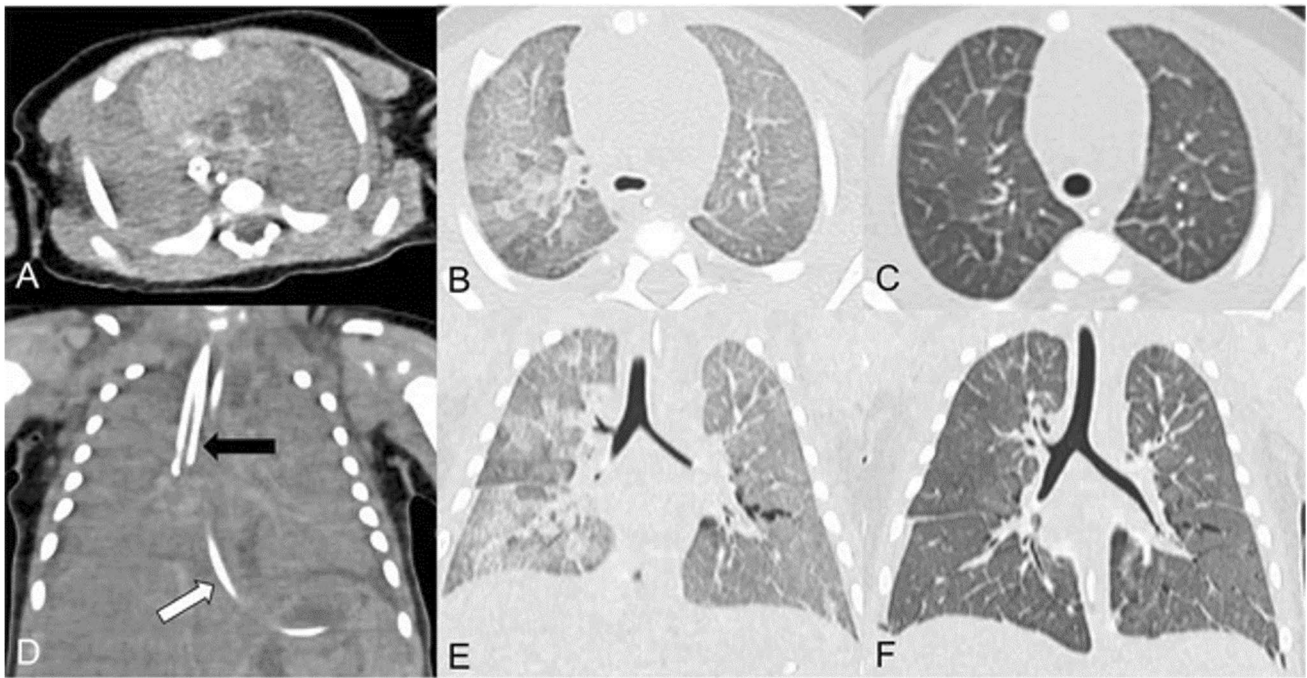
Ventilated postmortem computed tomography scan in a 28-day-old infant. Axial (a–c) and coronal (d–f) reformatted images are shown before ventilation (a, d), with the endotracheal tube tip in the right main bronchus (black arrow), after manual bag ventilation following endotracheal tube removal (b, e), and after mechanical positive end-expiratory pressure ventilation (c, f). A nasogastric
